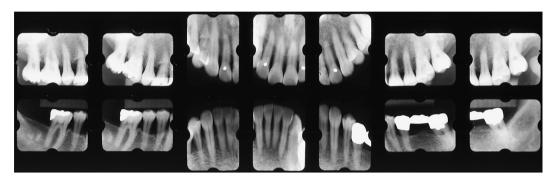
Radiographic view at baseline
